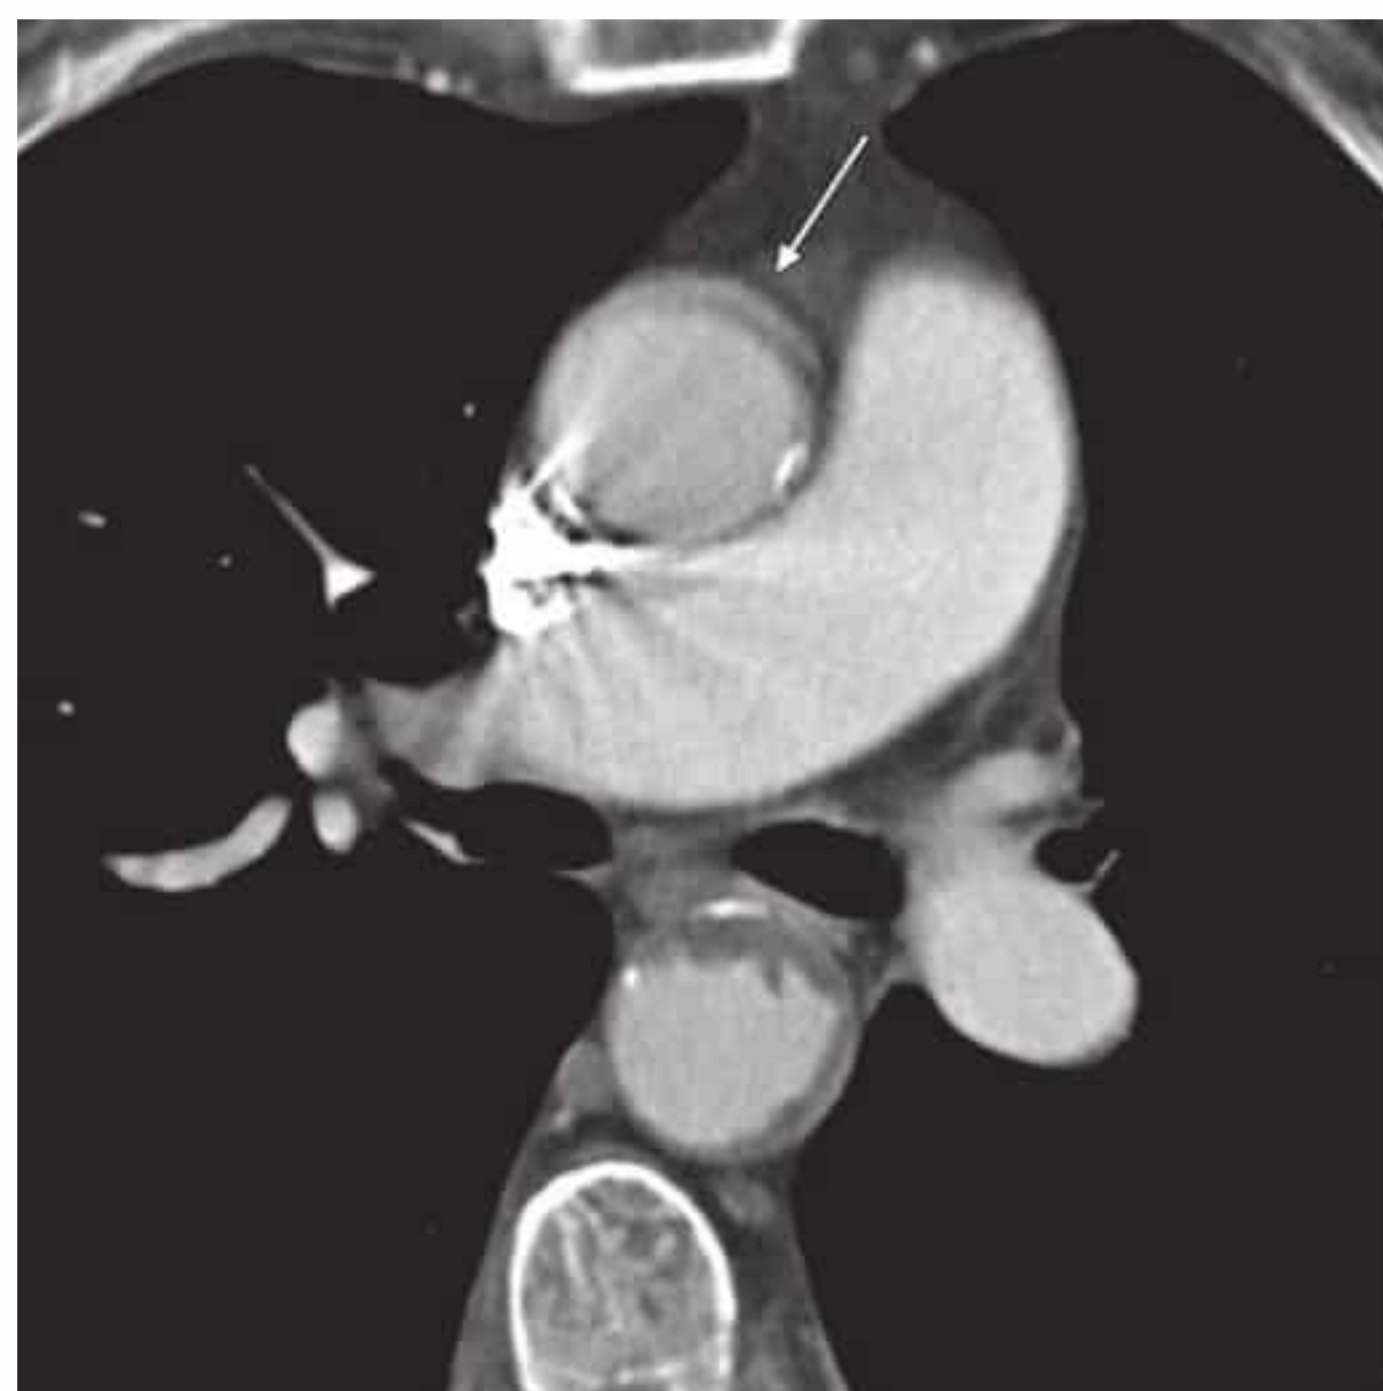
Contrast-enhanced CT at the level of the main pulmonary trunk demonstrates a calcified plaque with thrombotic deposits in the descending thoracic aorta due to severe atherosclerosis. A pulsation artifact in the ascending aorta mimics an intimal flap (arrow).
